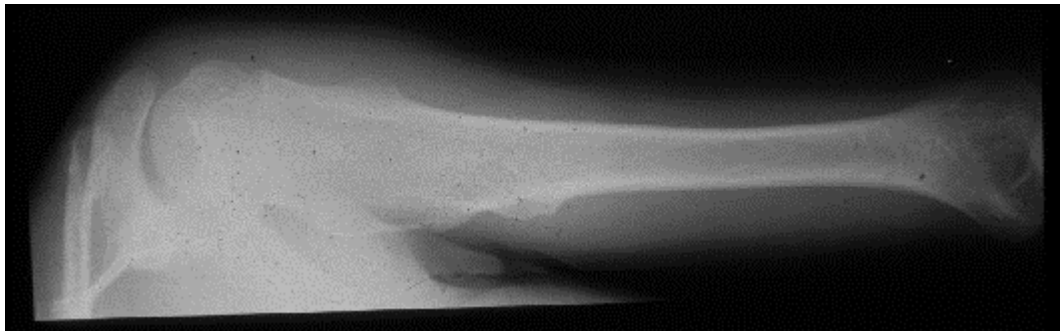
X-ray of the upper arm of a patient coming from a family with hereditary multiple exostoses (HME), demonstrating multiple osteochondromas (exostoses)
